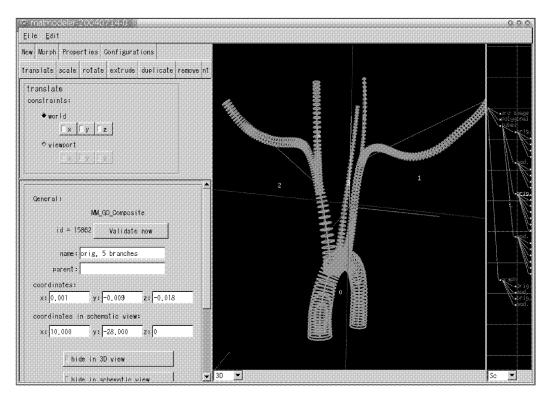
An overset CFD model of the aorta and its major branches built using the skeletal representation extracted from the MRI images semi-automatically.
